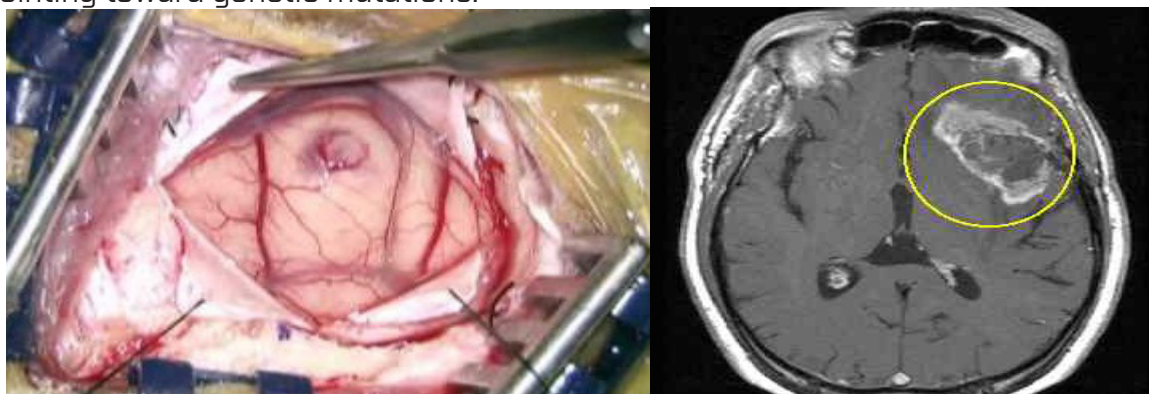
Glioblastoma during surgery (left), Glioblastoma seen in MRI (Right)
